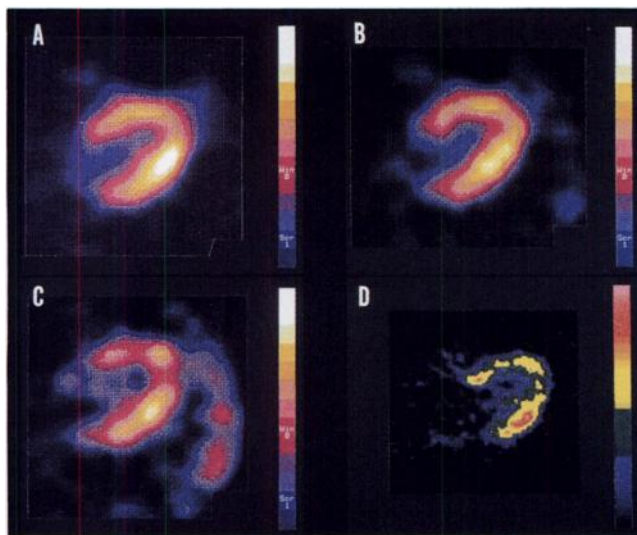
Reverse redistribution on 24-hr delayed imaging (Case 1 in Table 1). Reverse redistribution was found in the regions where ^{201}Tl activity was normal or slightly decreased on stress and 3-hr delayed images. Deterioration of FDG activity was observed on the regions with reverse redistribution. Thallium-201 stress imaging (A), ^{201}Tl 3-hr delayed imaging (B), ^{201}Tl 24-hr delayed imaging (chest wall is also seen in this image) (C), glucose-loaded ^{18}F -FDG imaging (the color scale in this image is different from others) (D).
